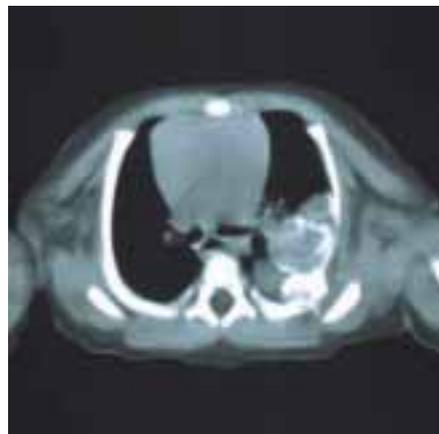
CT scan of a chest wall hamartoma in a three-day-old infant involving the inner aspect of a rib. The lesion has a radiodense component.
